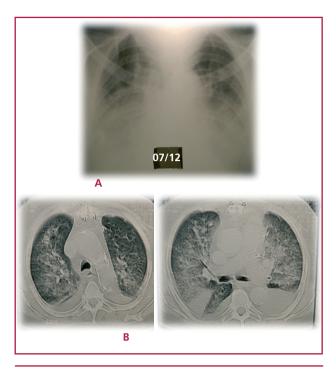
A. Chest x-ray with BOOP. B. Computed tomography scan with BOOP
